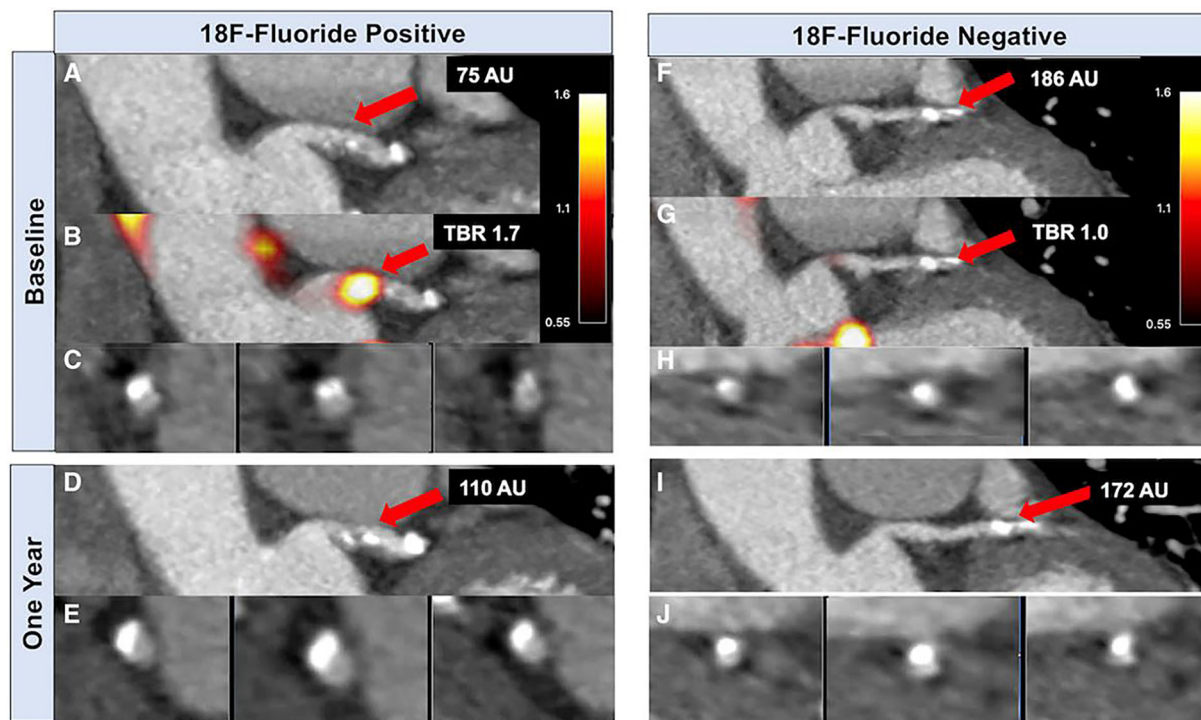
Baseline and repeat imaging of two coronary plaques in the same patient. Contrast-enhanced CT coronary angiography (A, C) and fused PET/CT (B) demonstrate NaF activity localized to calcification present in the left main stem. CT coronary angiography 1 year later (D, E) demonstrates increased CT calcification at this site. By contrast, CT coronary angiography (F, H) and PET/CT (G) showed a
